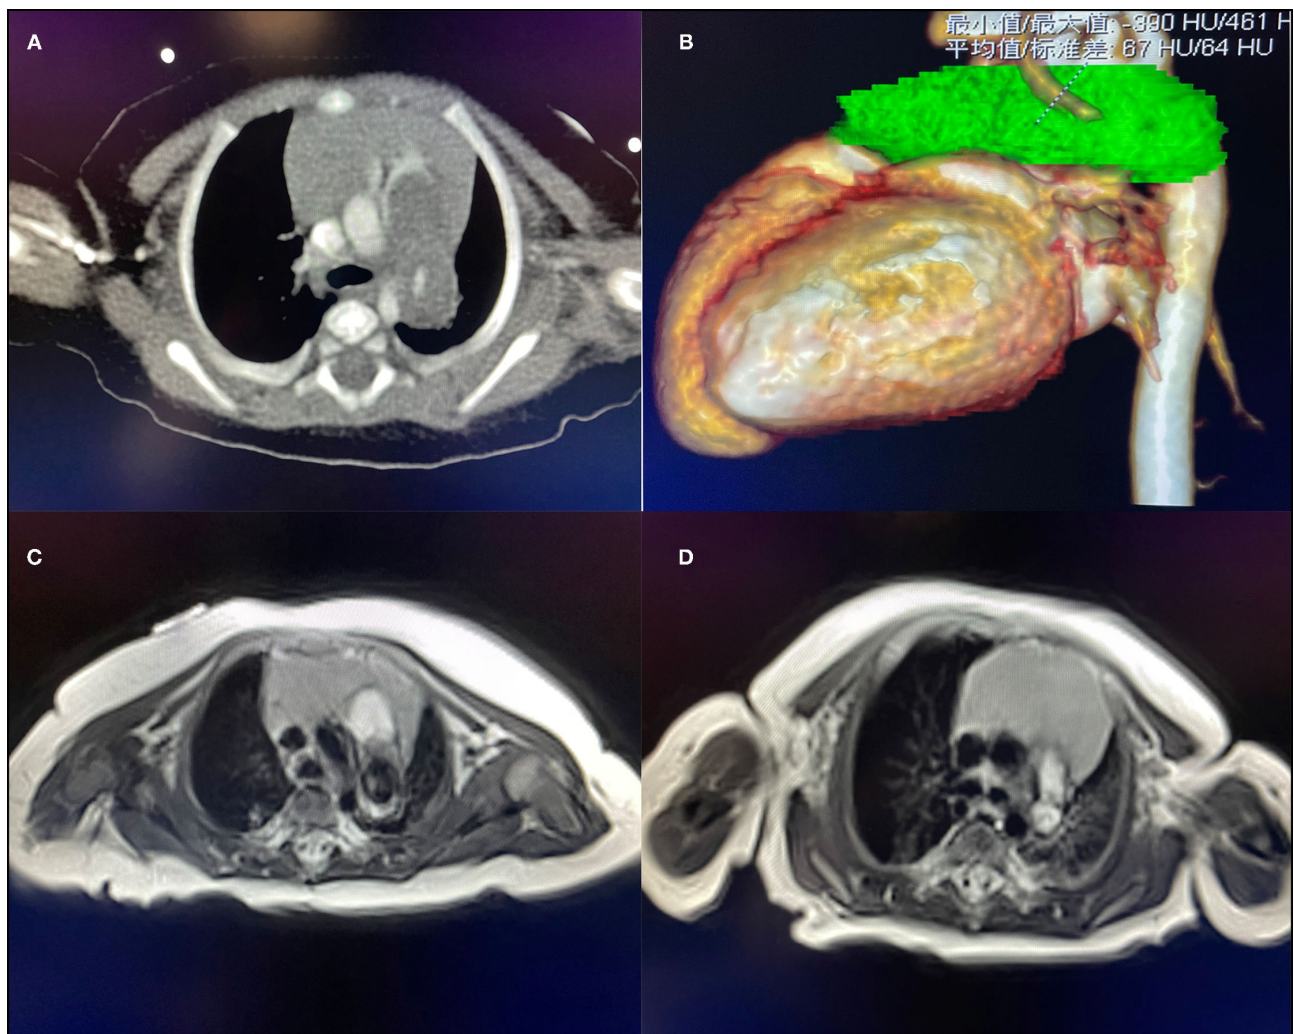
(A) CT suggests space-occupying lesions of the pulmonary artery. (B) The green part is the three-dimensional imaging of the lesion. (C) T1 image of the MRI of case 1 found a pulmonary artery space-occupying lesion. (D) T1 image of the MRI of case 2 found a pulmonary artery space-occupying lesion.
